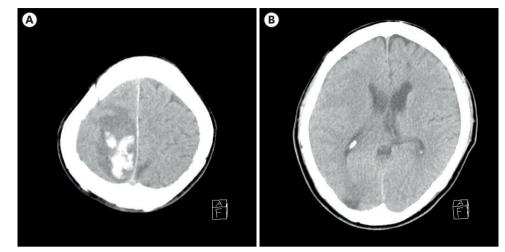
After symptoms develop, initial brain computed tomography findings of the patient. (A) New appearance of ICH (about 4.8cm in size) with surrounding edema in the right parietal lobe. (B) Transverse sinus view.
